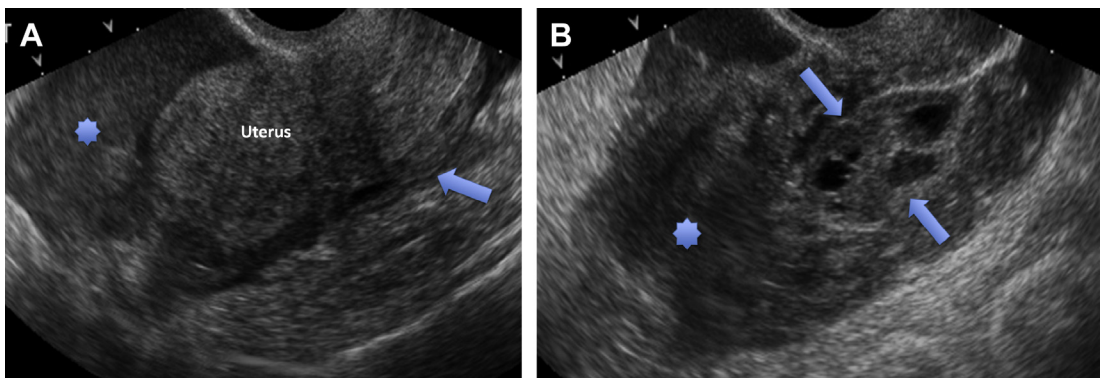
Hemoperitoneum associated with ectopic pregnancy. (A) Sagittal pelvic sonogram shows complex fluid (blood) surrounding the uterus. A large amount of blood is present in the anterior cul de sac (*asterisk*) and surrounding the uterine fundus. More echogenic, even solid appearing, blood is present in the posterior cul de sac (*arrow*). (B) The hemoperitoneum obscures the ovary. Sagittal pelvic sonogram depicts the ovary (*arrows*) surrounded by blood (*asterisk*). Follicles allow for identification of the ovary.
